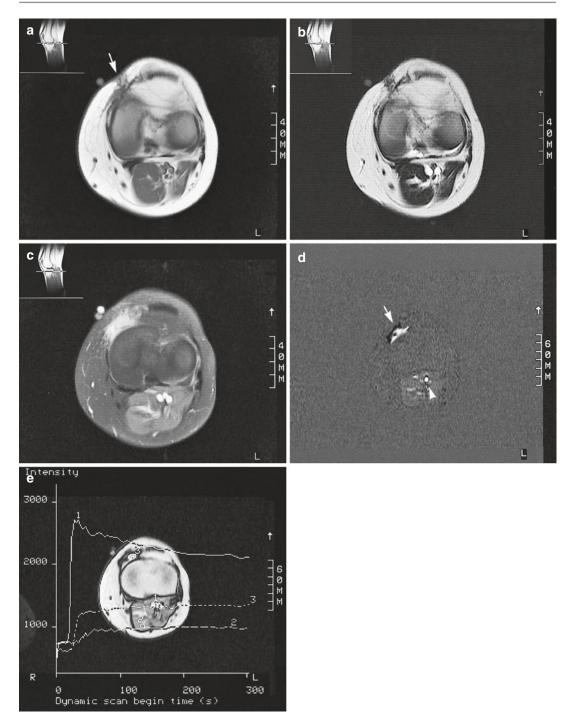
(a–e) Detection of recurrent tumor. A 40-yearold woman with recurrence of a previously surgically treated synovial sarcoma around the knee. (a) Axial spinecho T1-weighted image (TR 600 ms, TE 20 ms) at the level of the patella reveals a subcutaneous area of low signal intensity (*arrow*) abutting the femoral cortical bone. Differentiation of recurrent tumor tissue from granulation tissue is not possible. (b) Axial turbo spin-echo T2-weighted image (TR 4,587 ms, TE 150 ms) at the same level shows low signal intensity, which makes the possibility of local recurrence less likely. (c) Static contrast-enhanced, spin-echo T1-weighted image with fat-selective presaturation shows inhomogeneous enhancement of this area. It is not possible to discriminate between postoperative changes and recurrent tumor. (d) Subtracted, dynamic contrast-enhanced, gradient-echo image (turbo field echo; 0.5 T; TR 15 ms, TE 6.8 ms, TI 741 ms, flip angle 30°) at the same level, obtained 11 s
